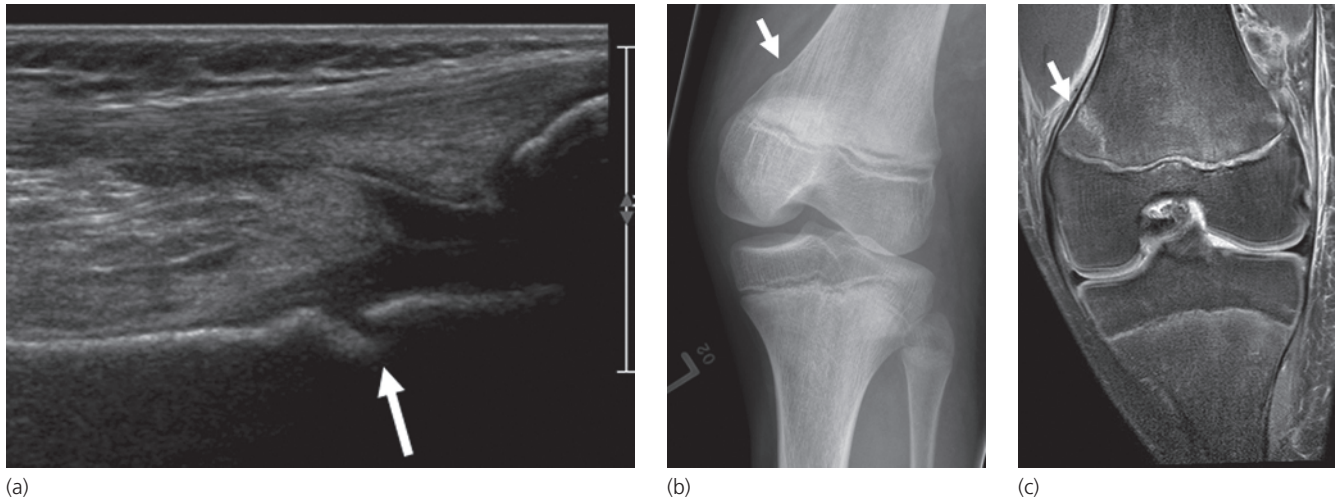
Ultrasound-detected fracture. (a) Sagittal image through the distal thigh shows a fracture (arrow) involving the distal femur, proximal to the patellofemoral joint. (b) AP radiograph confirms the fracture evident by cortical buckling (arrow). (c) Coronal fat-suppressed proton density image shows the bright fracture line and adjacent periosteal edema (arrow).
